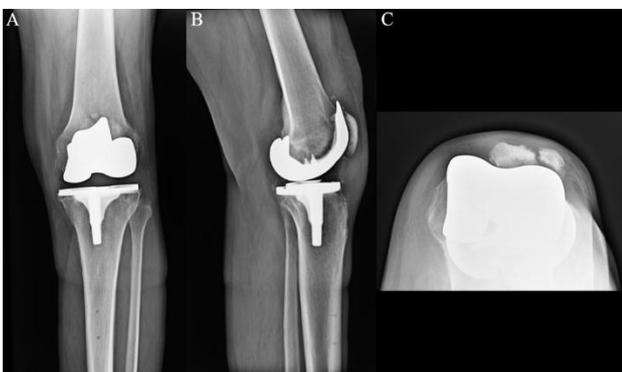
(A) AP, (B) lateral, and (C) sunrise radiographs one year post-operatively after total knee arthroplasty.
